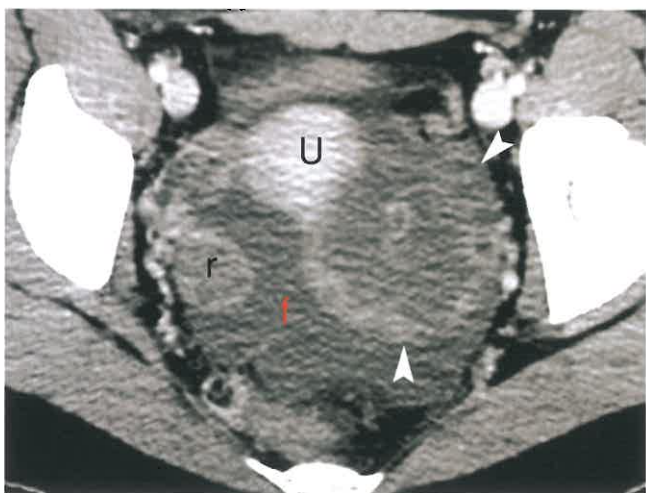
Ovarian Torsion. Axial postcontrast CT image shows a large cystic mass (arrowheads) arising from the left ovary with thickened poorly enhancing walls associated with a large volume of fluid (f) in the cul-de-sac. The patient was experiencing intermittent severe pelvic pain. Surgery reveals torsion of the left adnexa with a serous cystadenoma serving as the nidus for torsion. U, uterus; r, right ovary.
